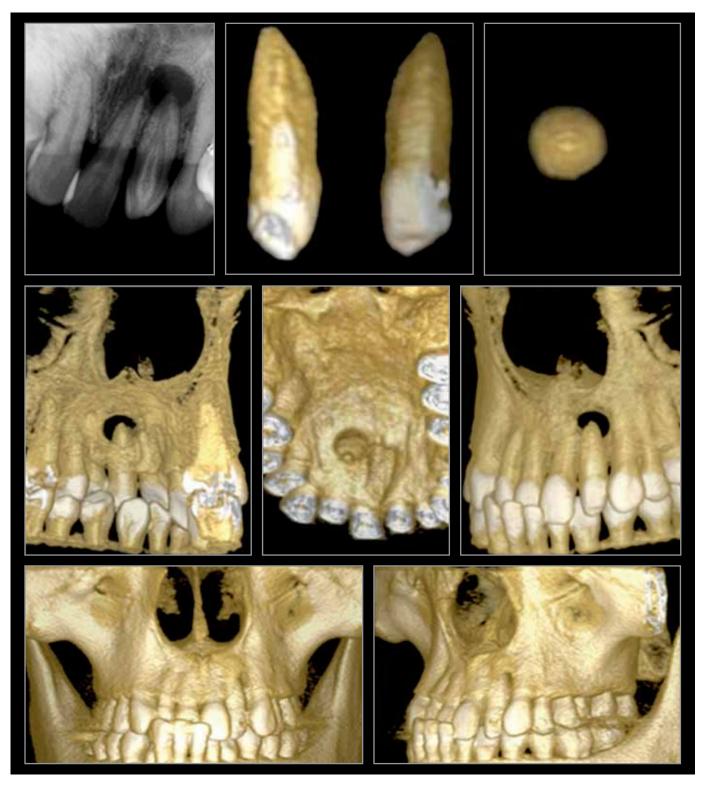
CBCT images reconstructions. Note apical, palatal and buccal bone cortical destruction.
